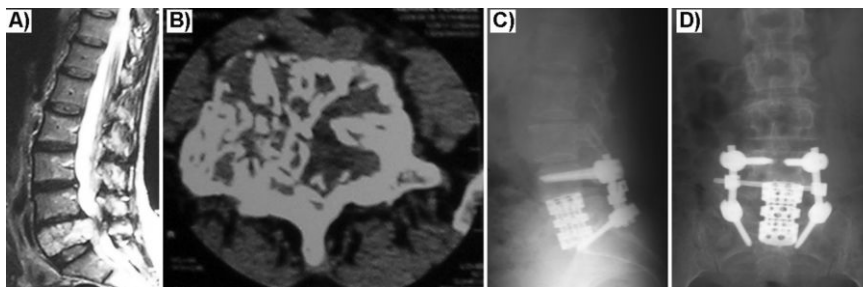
A 42-year-old female patient who had a hemangioma in her L5 vertebra (patient #7). A) Preoperative sagittal T2-weighted MR imaging of the patient; B) Preoperative axial CT imaging on the tumoral line of the L5 vertebra; C) Lateral radiographic view after the operation; D) Antero-posterior radiographic view after the operation.
